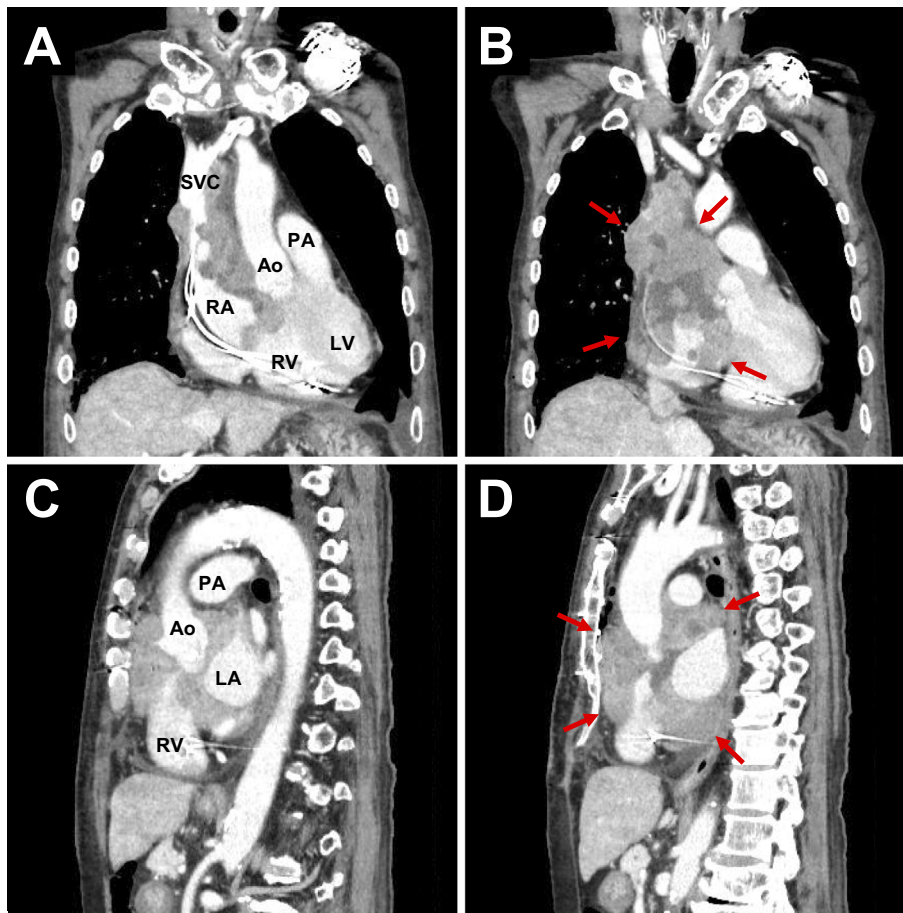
A) Contrast CT of the frontal plane showing the cardiac anatomy in relation to the tumor. B) A large mass involving the right atrium, the right ventricle, and the superior great veins (arrows). C) Contrast CT of the sagittal plane showing the cardiac anatomy in relation to the tumor. D) A large mass involving the area around the aorta as well as the right atrium and the right ventricle (arrows). Ao: aorta, LA: left atrium, LV: left ventricle, PA: pulmonary artery, RA: right atrium, RV: right ventricle, SVC: superior vena cava
